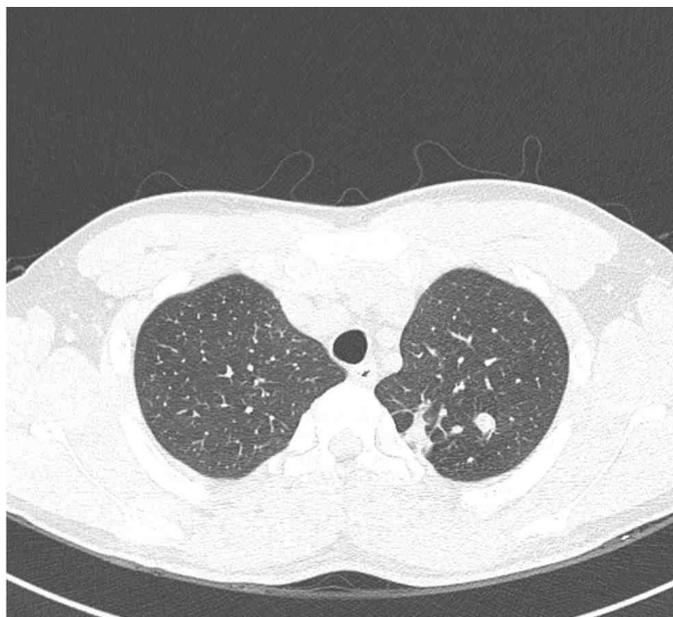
High-resolution CT image (1.0-mm section thickness) shows irregular fibronodular opacities in apicopost. segment of the left upper lobe. In high-resolution CT image, mediastinal lymph node enlargement is not observed.
